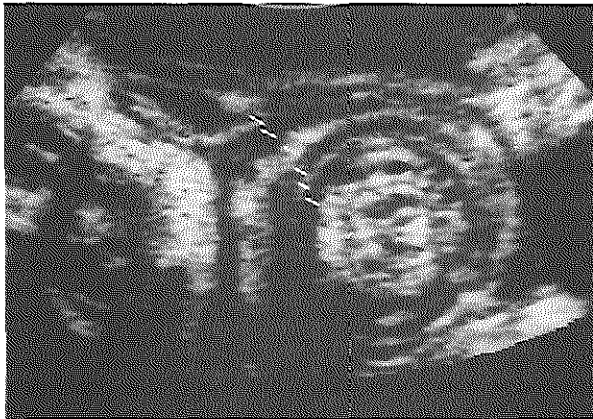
Cross-sectional ultrasound image through the intussusception, demonstrating alternating hyperechoic and hypoechoic rings (arrows).
